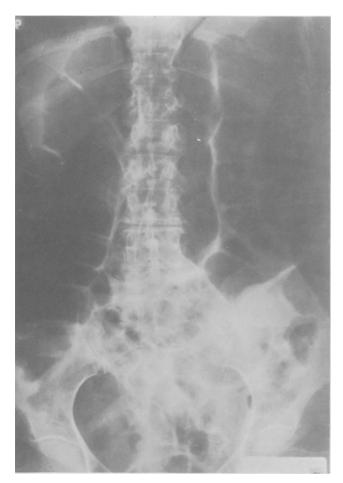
X-ray of the abdomen showing colon dilatation three years after sigmoid colectomy (Case 10).
